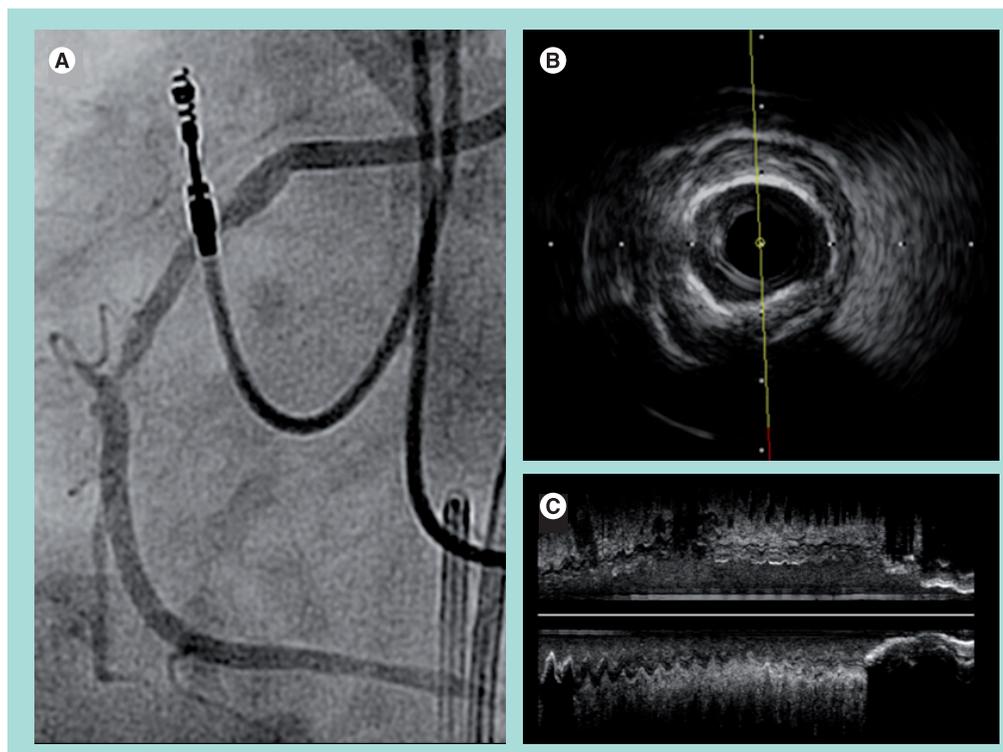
Undetected angiographic coronary calcification. (A) Right coronary angiogram showing the presence of a severe focal stenotic lesion in the midsegment, with unsuspected calcification. Intravascular ultrasound probe did not cross. (B) Intravascular ultrasound imaging at the site of the obstruction showing the presence of severe concentric calcific plaque. (C) Intravascular ultrasound long view of the same vessel.
